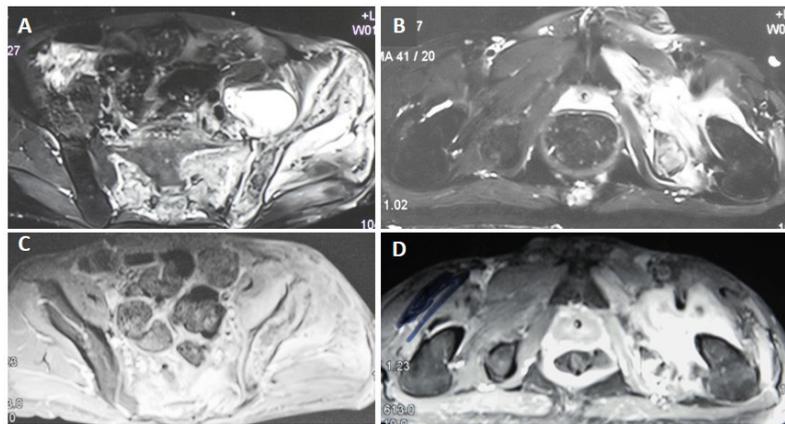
MRI images. Axial fat suppressed T2 images at the level of sacroiliac joints (A) and ischial tuberosity (B) at the time of admission showing left ilio-psoas collection and bony involvement of the sacrum and left hemipelvis (more on left side and left SI joint). Corresponding images post first debridement (C,D) showing mild reduction in the left side collection; however, the sacral involvement appears more extensive.
